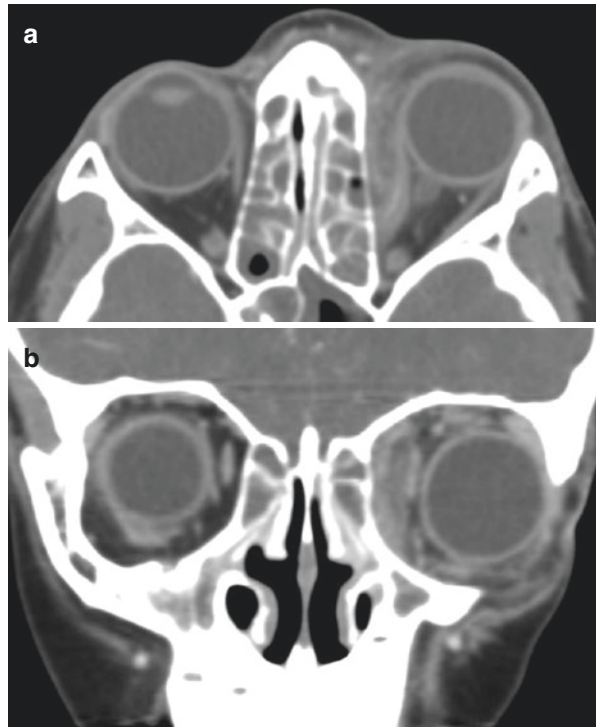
Young child with contrast-enhanced CT in axial (a) and coronal planes (b) demonstrates a rim-enhancing fluid collection along the left lamina papyracea and with medial displacement of the left medial rectus muscle
